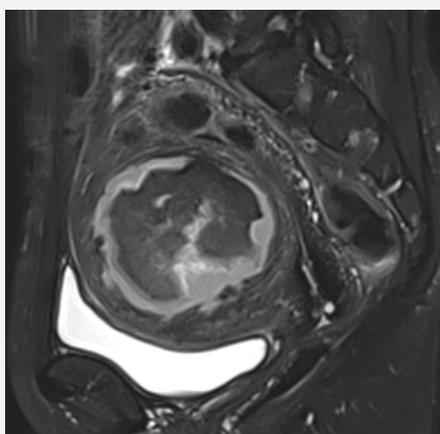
MRI of the intramural myoma of 79x66x77mm with heterogeneous characteristics.
